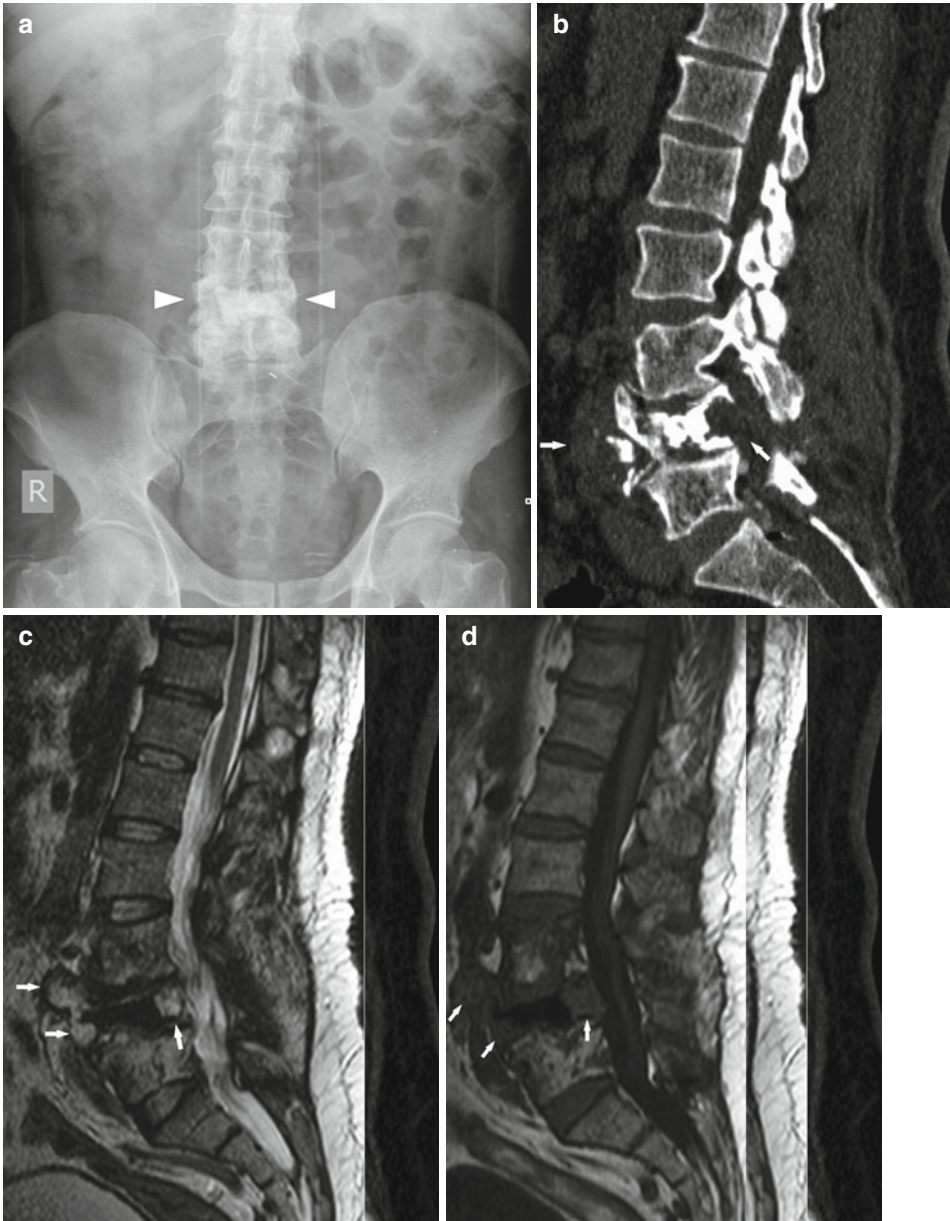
Anteroposterior plain X-ray (a) of a 43-year-old male patient with lumbar spinal hydatid disease. Decreased vertebral height and diffuse sclerosis is noticed at L4 vertebra (arrowheads). Sagittal reformatted CT image with bone window settings (b) demonstrates expansion and destruction at L4 vertebra with both sclerotic and lytic areas
